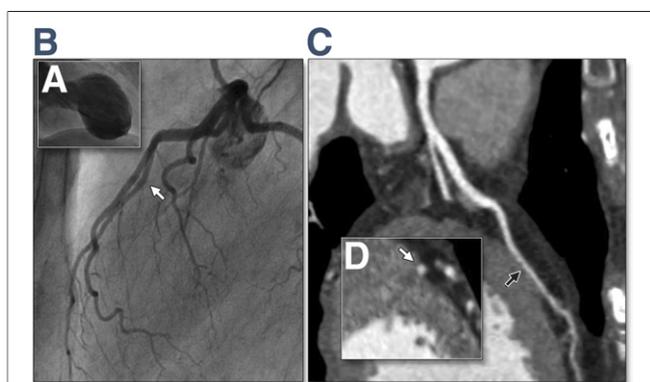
Myocardial Bridging With Partial Encasement by CTA Missed by Angiography
